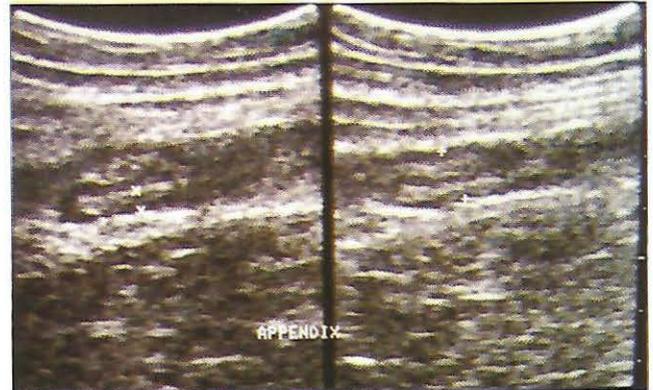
Sonogram showing inflamed appendix in the right iliac fossa. Wall thickness of 4mm and a diameter of 9mm were associated with exquisite tenderness.
